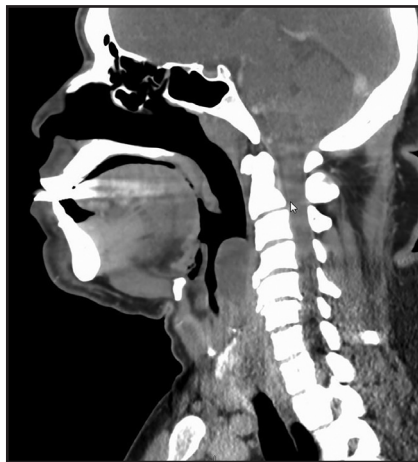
Sagittal CT image shows a low-attenuation mass anterior to the cervical vertebrae, causing significant narrowing of the airway.
